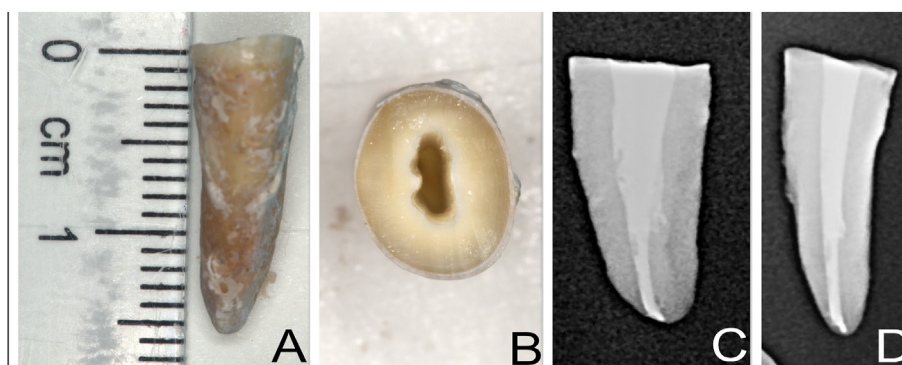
(A) Post decoronation 16 mm root. (B) Root cross-sectional post canal preparation view. (C) and (D) Post-obturation periapical radiographs.
